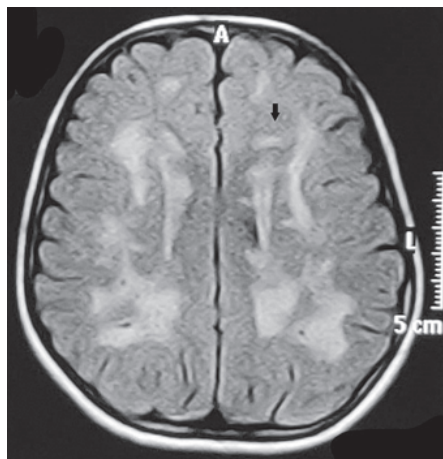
MRI brain axial FLAIR image - Well defined multifocal white matter hyperintensities. Note the linear pericallosal hyperintensities (Black arrow)
